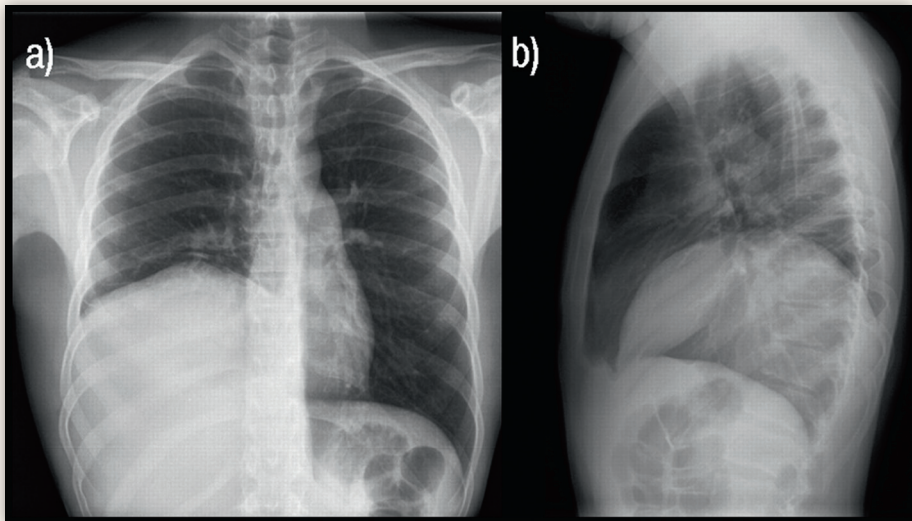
a) Postero-anterior and b) lateral chest radiographs at presentation.
